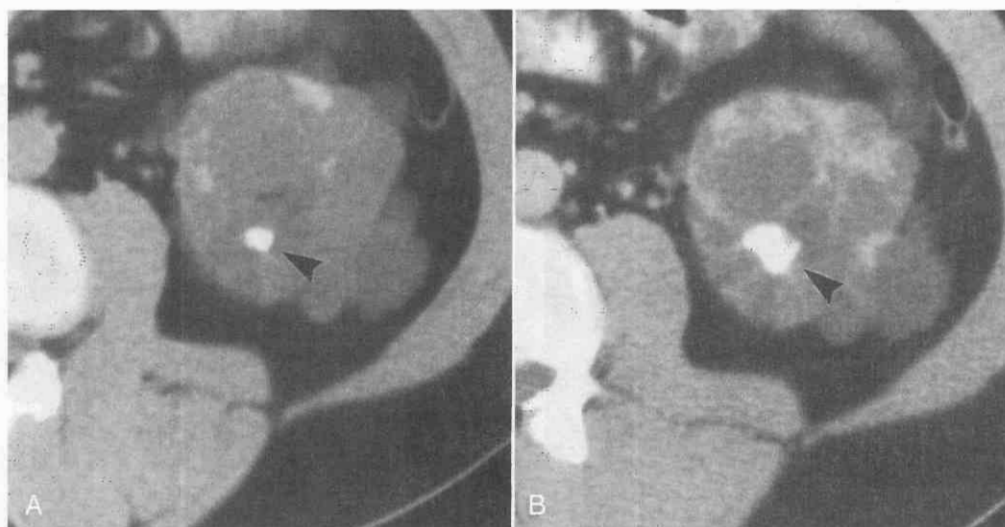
Autosomal dominant polycystic kidney disease with a calculus in the lower pole of the left kidney. *A*, An unenhanced CT scan shows a small, rounded calcification (arrowhead). *B*, A contrast-enhanced CT scan reveals that the calcification is located in an opacified calyx (arrowhead). (From Levine E, Grantham JJ: Calcified renal stones and cyst calcifications in autosomal dominant polycystic kidney disease: Clinical and CT study in 85 patients. *AJR Am J Roentgenol* 159:77-81, 1992.)
